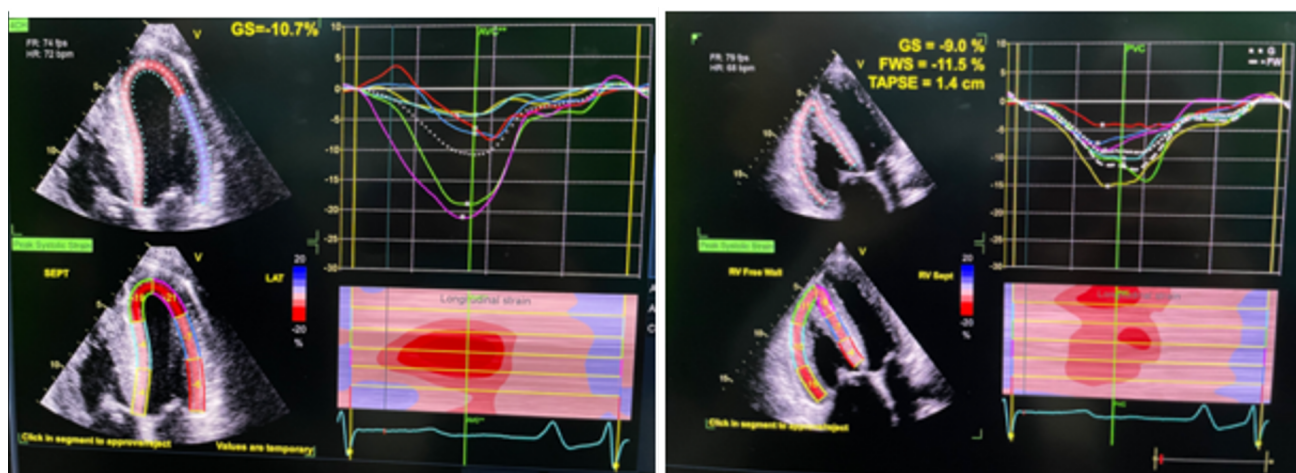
Speckle tracking echocardiography showed RV Free Wall GLS -11,5% (left) and LV GLS -10.7% before BPV (right).
